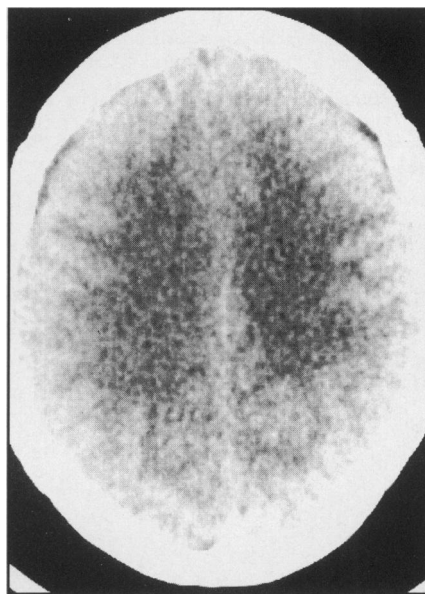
(b) Axial CT scan (level equivalent to Figure 2(a)) showing no visible abnormality.
